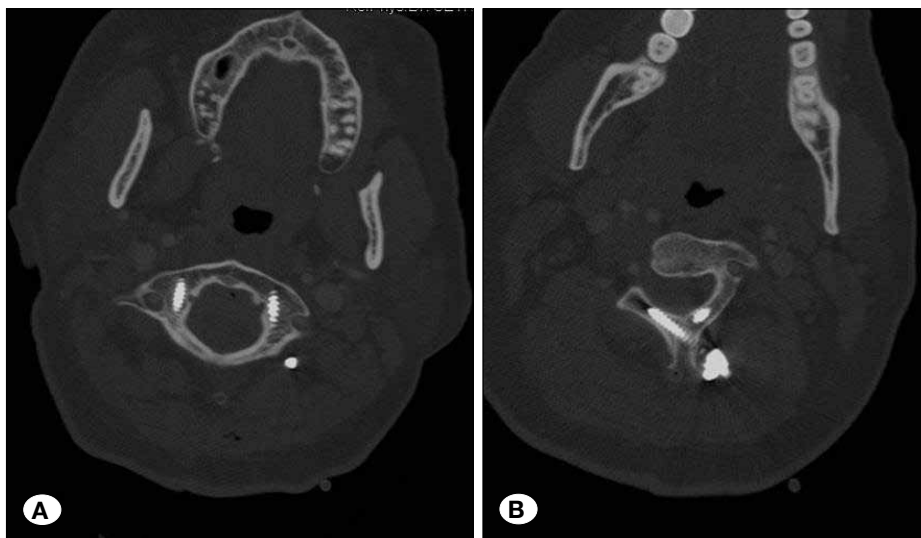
A,B) Postoperative axial CT scans shows precise screw insertion of bilateral C1 lateral mass via the posterior arch combined with bilateral C2 translaminar screws.
